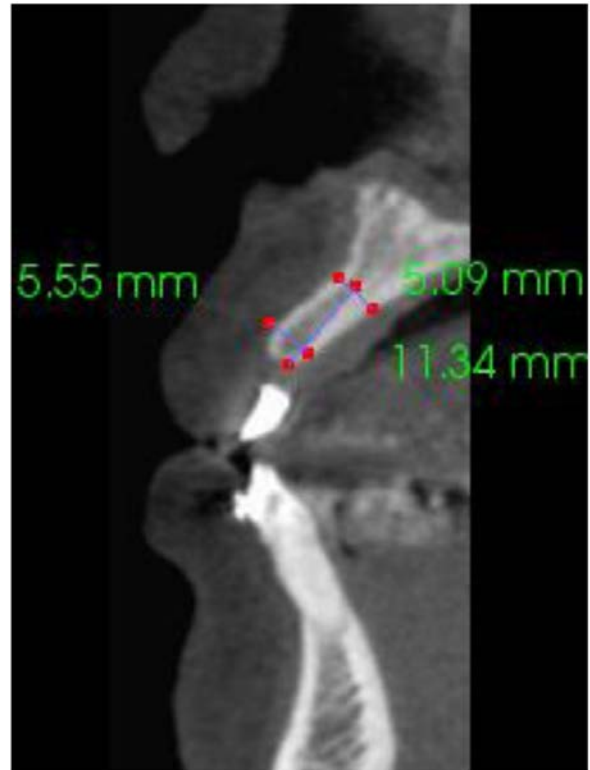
CBCT scan images for implant placement planning.
